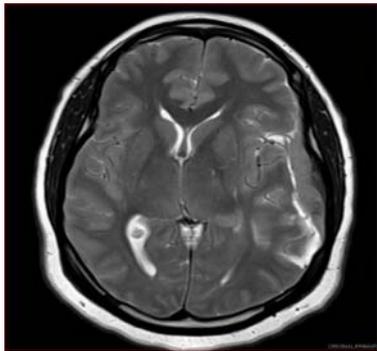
3T Brain MRI Axial T2 WI: Left convexity elliptical extra axial isointense lesion(Arrow).
